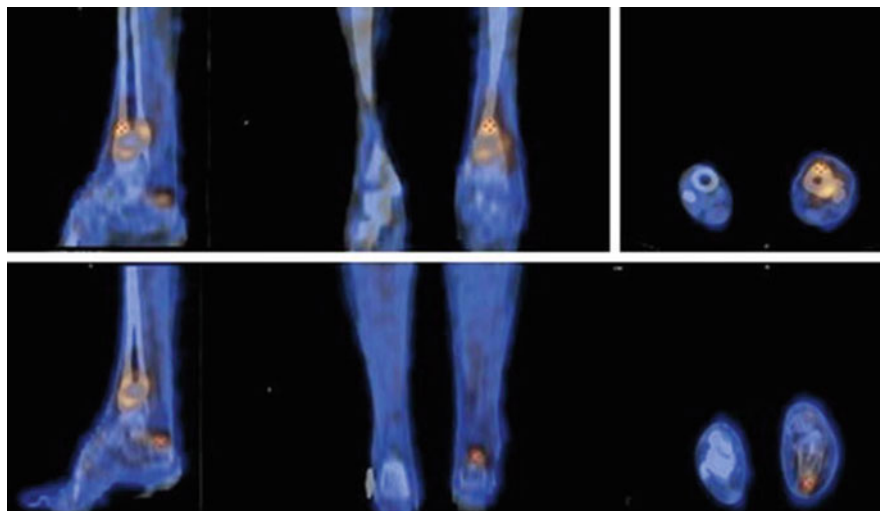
Radiolabelled WBC for infection imaging. Sagittal (*left*), coronal (*middle*), and transaxial (*right*) SPECT/CT images of a patient with post-traumatic osteomyelitis of the left tibia. A focal site of increased [^{99m}Tc]Tc-HMPAO-labelled WBC uptake is evident at the distal tibia; a smaller additional focus of [^{99m}Tc]Tc-HMPAO-labelled WBC uptake is also evident at the tibial-calcaneal joint. Reproduced from Erba & Israel [64] with permission. © 2014, Italian Association of Nuclear Medicine and Molecular Imaging
